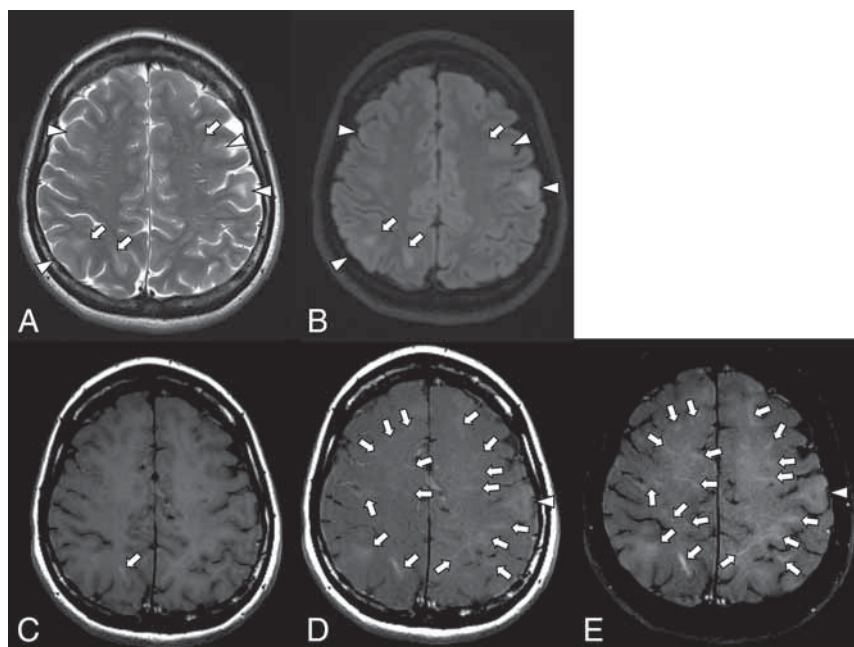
Patient 4. A 29-year-old woman. Axial T2WI (A), FLAIR (B), TIWI (C), TIWI-MTC (D), and TIWI-CHES (E). T2WI and FLAIR images demonstrate swollen cortices, some of which are accompanied by subcortical hyperintensities, representing cortical tubers (A and B, arrowheads). Linear hyperintensities in the subcortical area extending to the ventricle are observed, representing the RMLs (A and B, arrows). On TIWI, an RML is found in the right parietal lobe (C, arrow). TIWI-MTC and TIWI-CHES are able to detect more RMLs than TIWI, T2WI, and FLAIR (D and E, arrows). The RMLs are more apparent on TIWI-CHES than on TIWI-MTC (D and E, arrows). Although no obvious cortical tuber is shown by TIWI, both TIWI-MTC and TIWI-CHES detect a cortical tuber as a slight hyperintensity (D and E, arrowheads).
